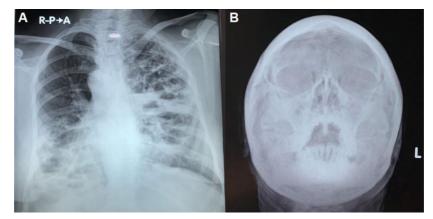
Chest X-ray showing dextrocardia with bronchiectasis (A). X-ray of paranasal sinuses (Water's view) showing diffuse haziness of all sinuses (B).
